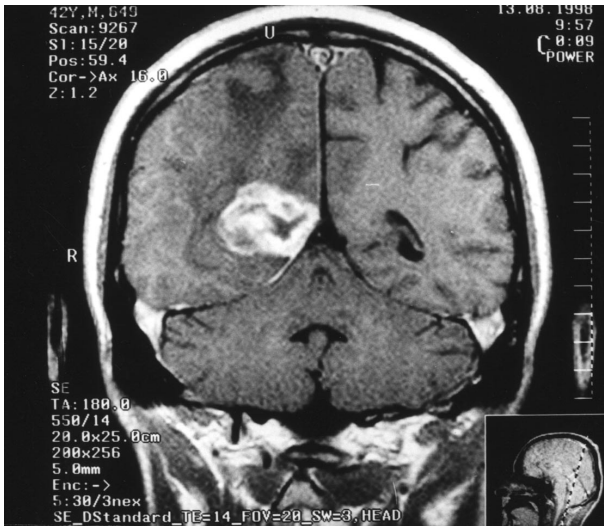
Non-homogenous tumour in right occipital area, strongly enhanced by gadolinium injection, Fig. 2a. In intraoperative USG (Fig. 2d) hyperechogenic lesion, again non-homogenous. Extensive oedema around the tumour is visible in MRI (Fig. 2c), with mass affect evidenced as compression of posterior horn of right lateral ventricle.
